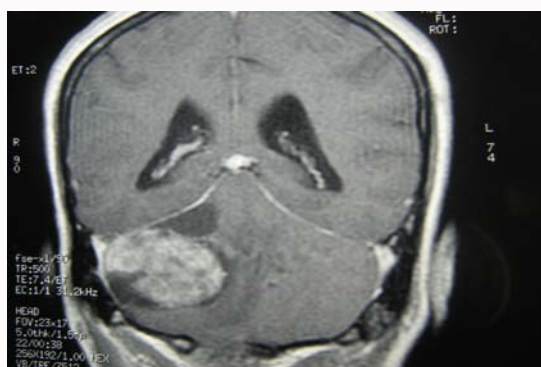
Coronal T1W MRI obtained after gadolinium administration revealing an irregular enhancing lesion in the right cerebellar hemisphere.
